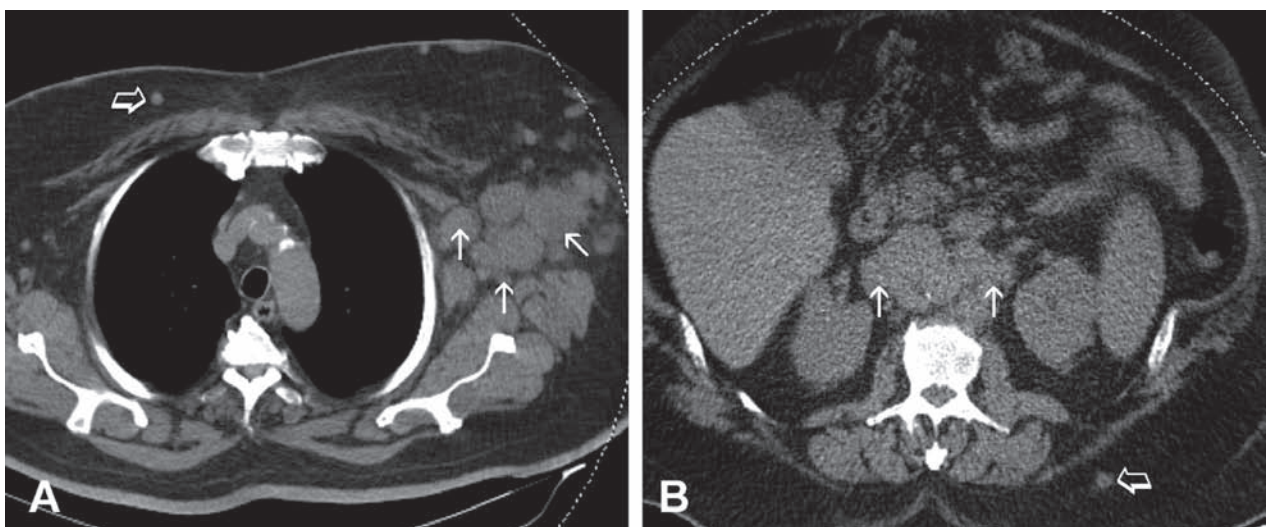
Chest CT image (A), shows pronounced enlargement of left axillary lymphnodes (arrows). Abdominal CT image (B), shows multiple enlarged paraaortic lymphnodes (arrows). Subcutaneous nodules (open arrows) are also noted on both chest and abdominal CT images.
